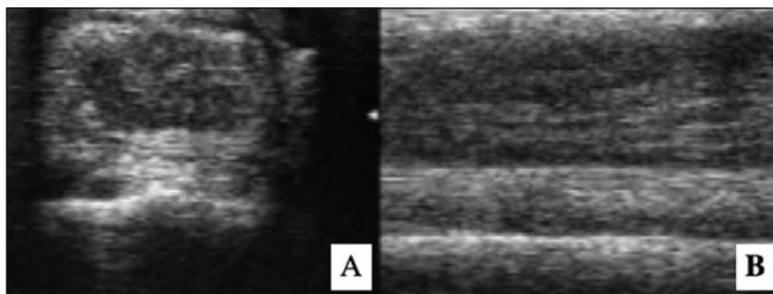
Transverse (A) and longitudinal (B) ultrasonographic images of the suspensory ligament in a Standardbred racehorse with MSD.
